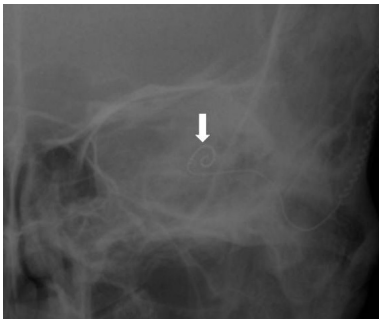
Postoperative transorbital X-ray. Imaging performed immediately after cochlear implantation revealed a fully inserted electrode (white arrow) in the cochlea on the left side.
